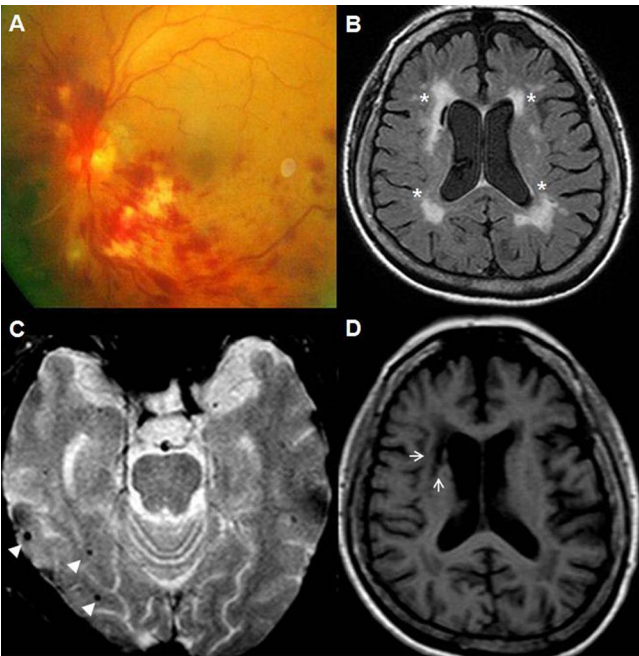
Cerebral small vessel disease in old patient with RVO. (A) A case of central RVO with flame-shaped retinal hemorrhage in a 78-year-old woman. (B) White matter hyperintensities (Fazekas grade 3) on brain MRI (FLAIR image; *white asterisks*), (C) multiple cerebral microbleeds on T2-weighted brain MRI (*white arrowhead*), and (D) silent lacunar infarct on T1-weighted MRI (*white arrow*) corresponding to cerebral small vessel disease.
